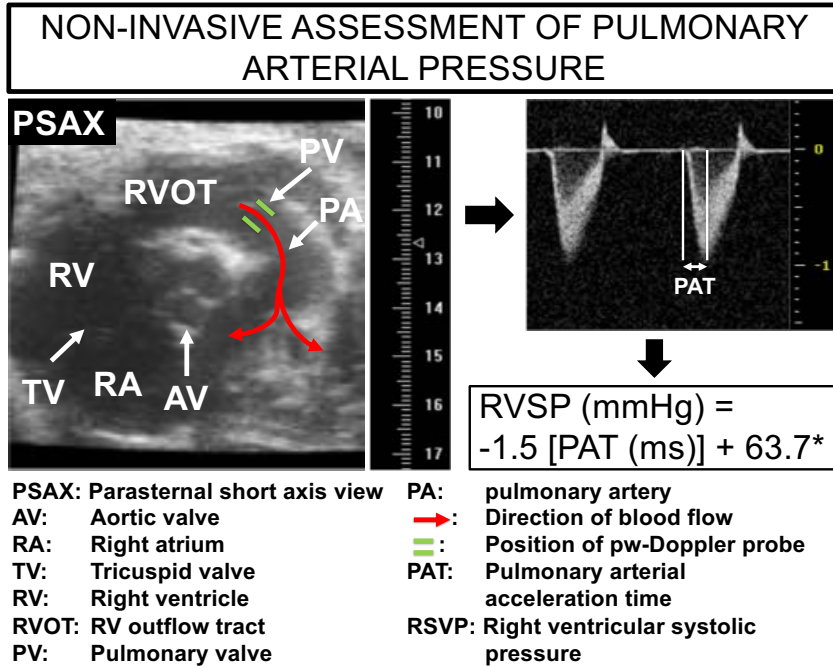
Non-invasive assessment of PAP. To allow for repetitive measurements of PAP, pulmonary arterial acceleration time (PAT) was assessed as a surrogate parameter for PAP/RVSP as described and verified by Thibault et al. [5]: Two-dimensional images of the pulmonary infundibulum were obtained from the parasternal short-axis view at the level of the aortic and pulsed-wave Doppler (pw-Doppler) recording of the pulmonary blood flow was obtained after positioning the pw- Doppler sample at the tip of the pulmonary valve leaflets and aligned to maximize laminar flow (Figure S1). As PAP/RVSP increases, PAT shortens. PAT and RVSP were shown to exhibit a linear correlation ($RVSP [mmHg] = -1.5 \times PAT [ms] + 63.7$). To facilitate understanding, results were presented as PAT (ms) and as calculated RVSP* (mmHg) with a cutoff of 21 ms (PAT)/ 32 mmHg (RVSP*) between normal and elevated PAT [5].
